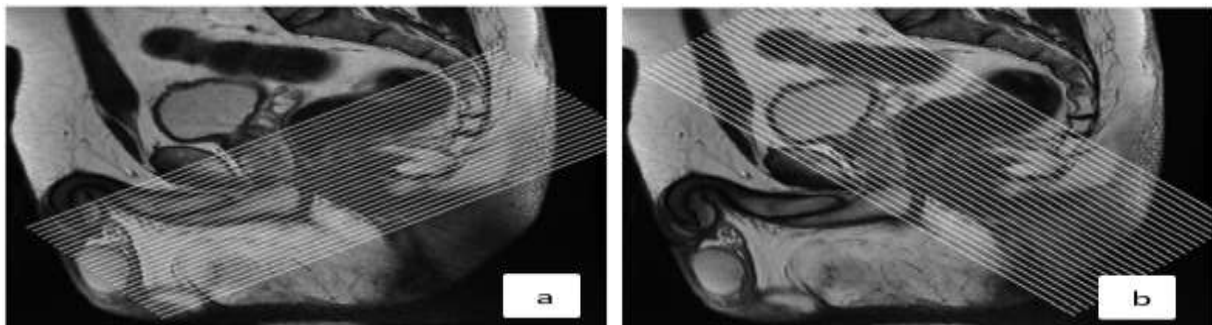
Sagittal MRI sequence images: a. T2W TSE, b. T1W TSE
